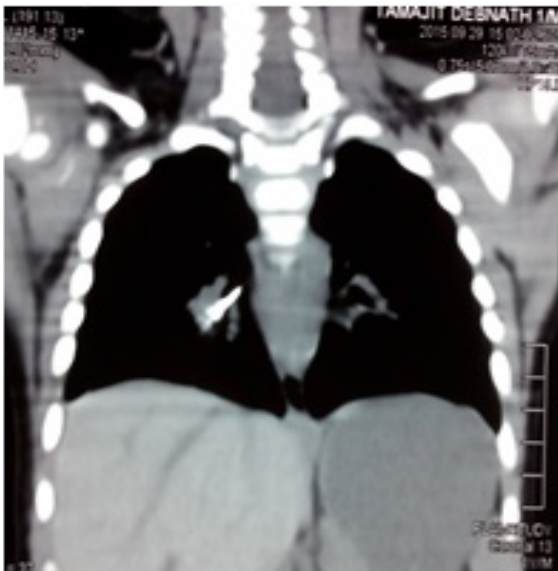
CT chest pin in right lower bronchus.
